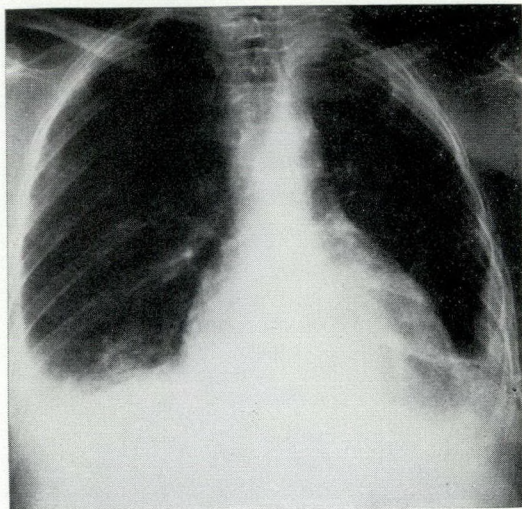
Posteroanterior chest radiograph, September 24, 1963. Following aspiration of the right pleural effusion, an enlarged cardiac silhouette compatible with pericardial effusion is apparent, particularly in comparison with Fig. 1. This, however, was not recognized until after diagnosis by needle aspiration of the pericardial space.
